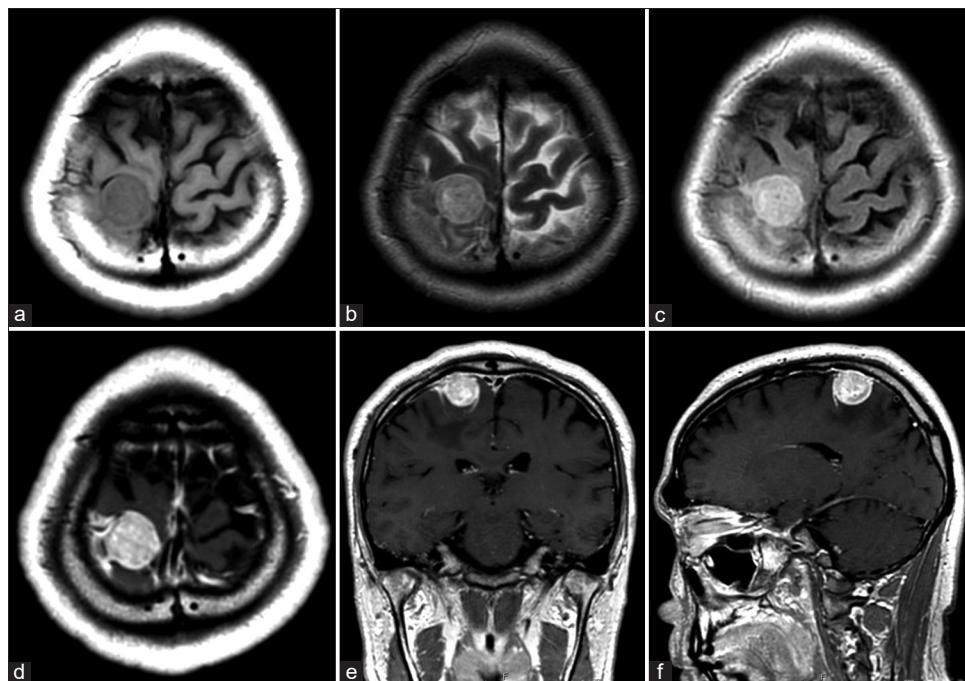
Preoperative magnetic resonance images (MRI). Preoperative MRI showed right frontal mass lesion. The lesion was isointense in T1-weighted MRI (a), hyperintense in T2-weighted MRI (b), hyperintense in fluid attenuation inversion recovery image (c), and homogenous enhanced with gadolinium intravenous injection (d: Axial image, e: Coronal image, and f: Sagittal image).
